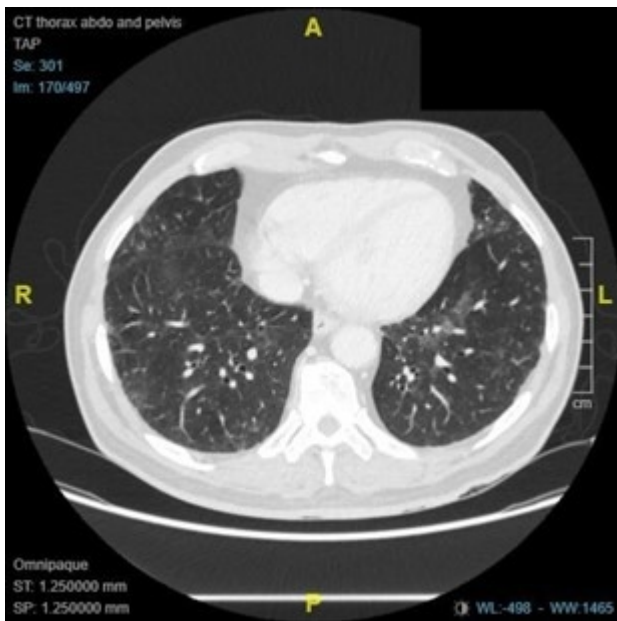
Baseline CT Thorax pre-treatment
